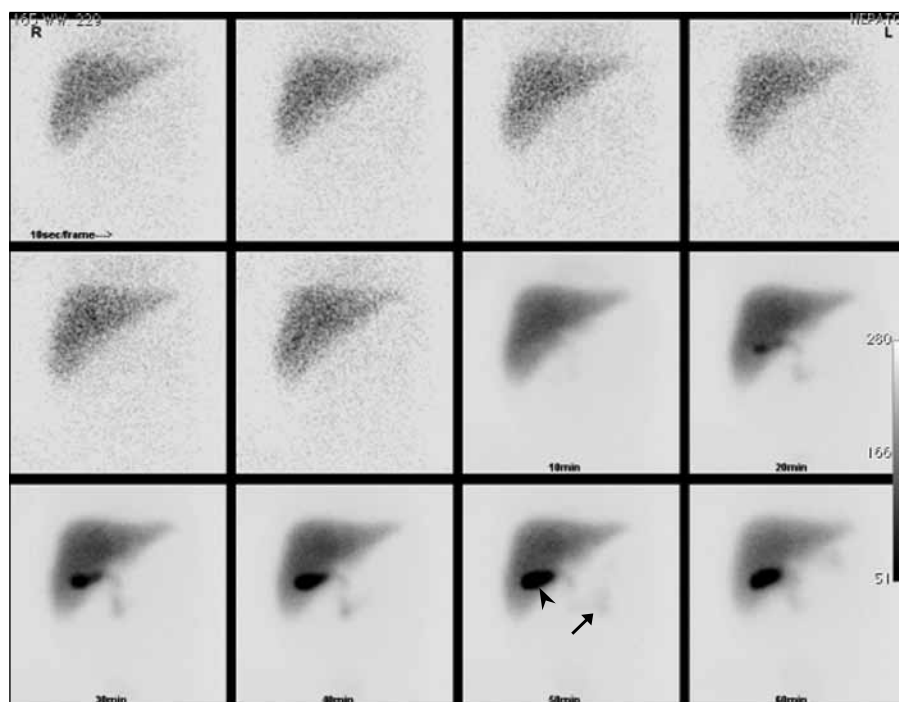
Hepatobiliary scintigraphy with radiotracer visualised in gallbladder (arrowhead) and duodenum (arrow) within 60 minutes, hence a negative study for biliary atresia. The displayed images were formatted as 10 seconds per frame from 0 to 60 seconds, and then 10 minutes per frame up to 60 minutes.
